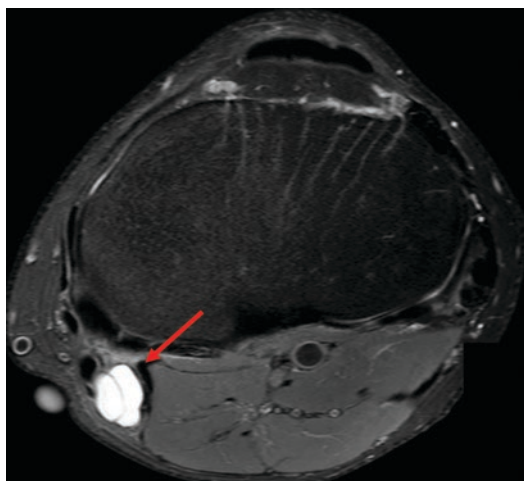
MRI of a ganglion cyst at the ischiocrural muscles near the knee (see arrow)
